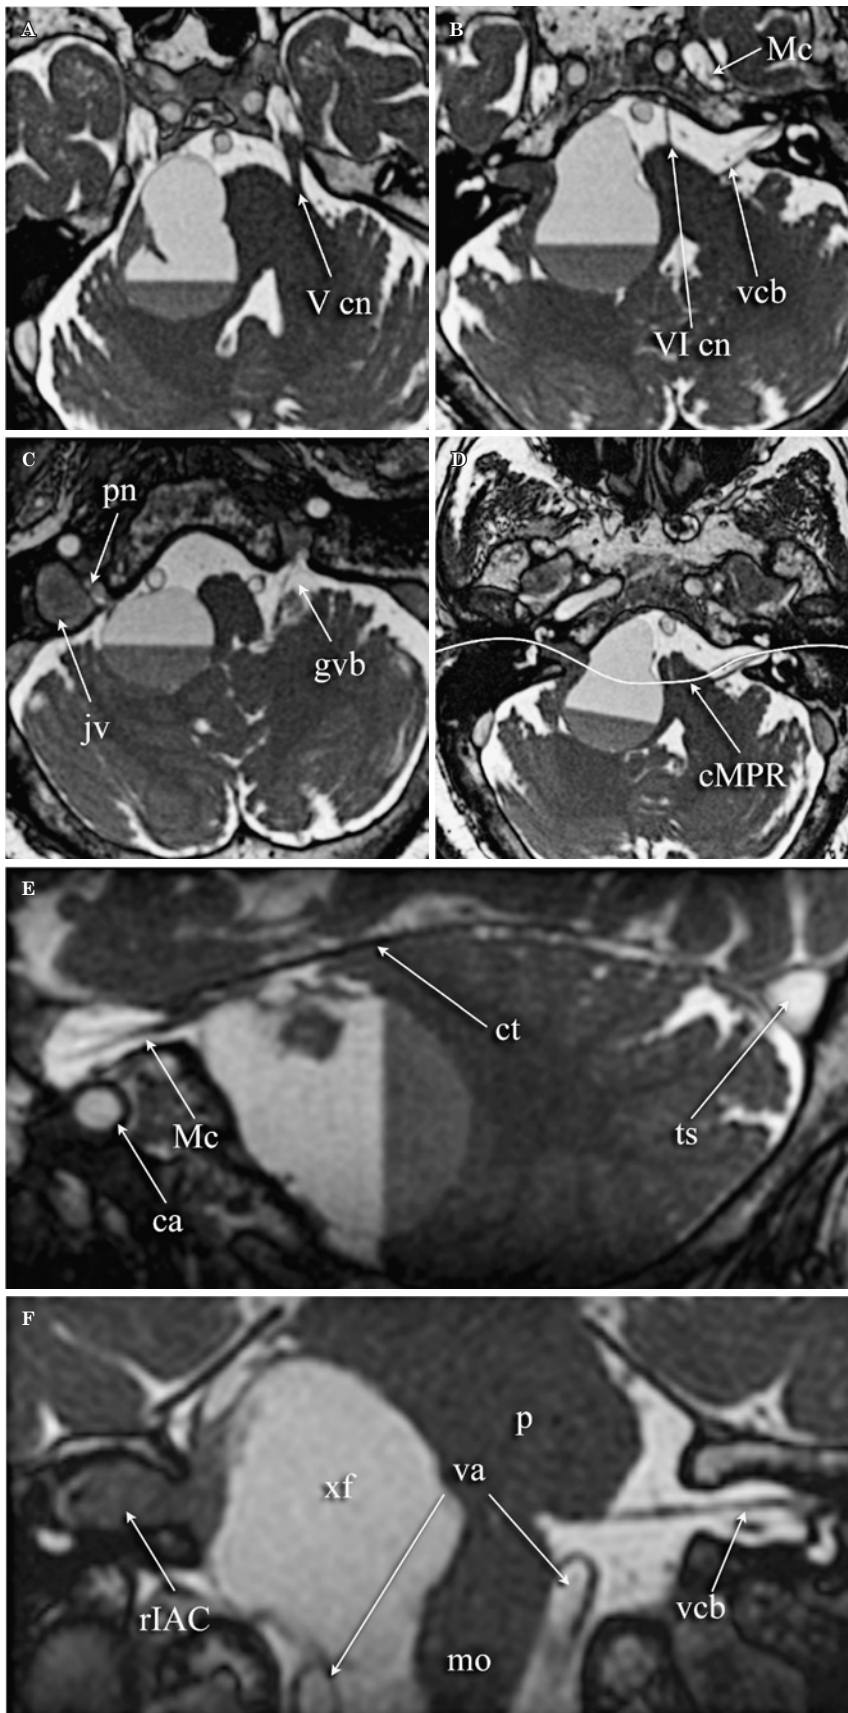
Axial (A-C) and sagittal (E) MPR images from the volumetric FI-ESTA sequence (0.8 mm isotropic, heavily T2-weighted acquisition). F) Sagittal curved MPR [cMPR] obtained from the plane shown in (D). V cn: left trigeminal nerve leaving the pons [p] and entering Meckel's cave [Mc]. The right preganglionic trigeminal nerve was strongly rostral-medially displaced (trigeminal ganglion and all the major divisions inside the right Mc were normal). VI cn: left abducens nerve entering Dorello's canal with a normal extension (not shown) beneath Grüber's ligament up to and across the cavernous sinus. Normal left glossopharyngeal and vagus nerve branches [gvp]; right branches are displaced since the mass extends caudally up to obstructing the ostium of the pars nervosa [pn] of the jugular foramen; jugular vein [jv] inside the pars vascularis of the foramen. Vestibulo-cochlear branches [vcb]; cerebellar tentorium [ct]; transverse sinus [ts]; carotid artery [ca]; vertebral artery [va]; medulla oblongata [mo].
